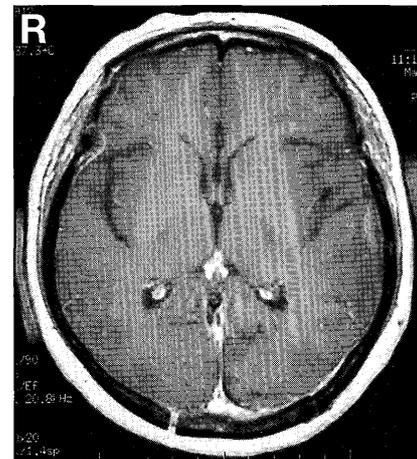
Postoperative T₁-weighted magnetic resonance image with contrast medium showing the tumor of the pineal region has been completely removed, and the obstructive hydrocephalus has also improved (performed in 3 days after surgery).
